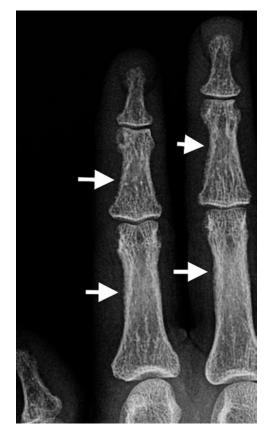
AP radiograph of right hand, magnified, demonstrating changes of subperiosteal resorption (*arrows*)
